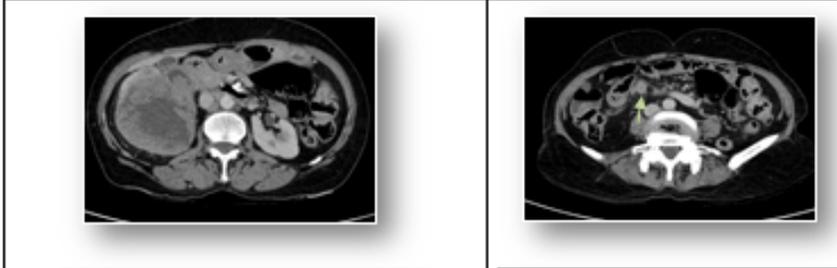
Axial nephrographic phase CT images of the same patient showing extensive feathery urothelial thickening in the dilated collecting system of right moiety of horseshoe kidney. The right ureter also shows wall thickening with peri-ureteric fat stranding (arrow). There was super-added infection in this case of Transitional Cell Carcinoma.
